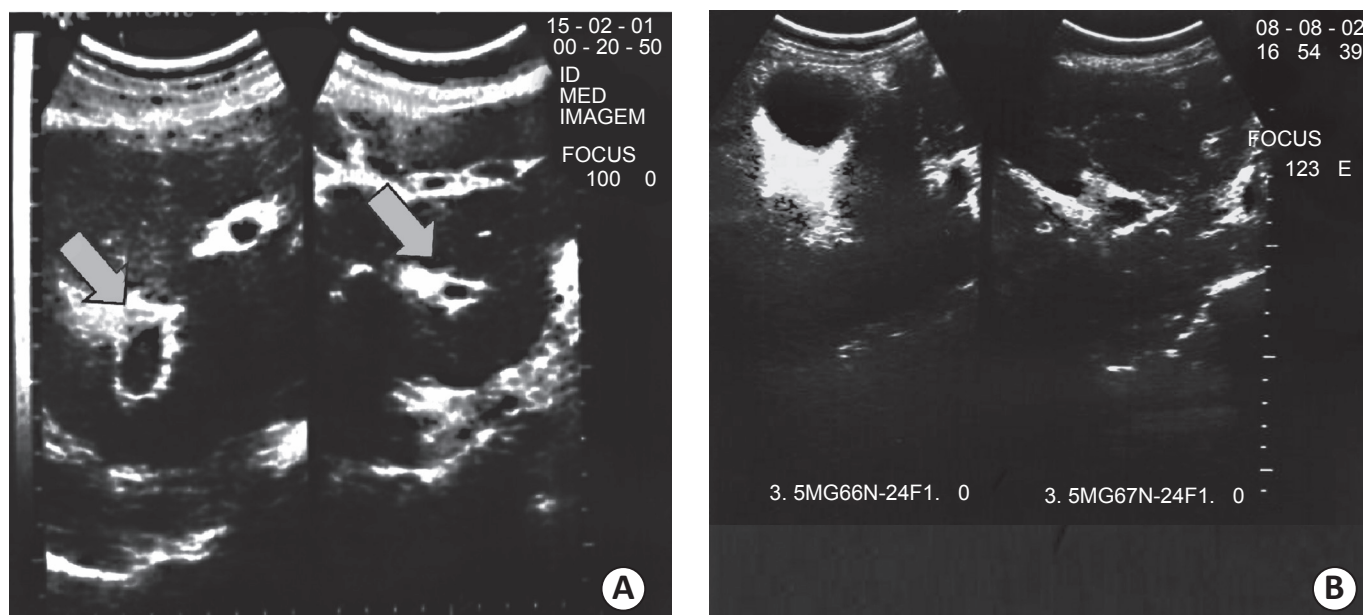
Ultrasound features of periportal fibrosis patterns E (A) and D (B), according to Niamey's classification.
